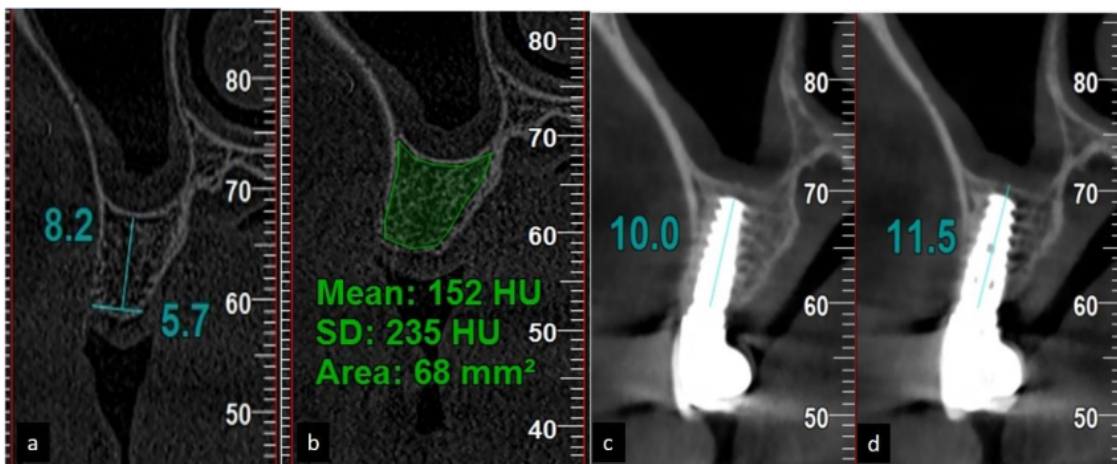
a and b. Preoperative CBCT showing residual bone height of about 8.2 mm; c and d. 1 year Post- operative CBCT
